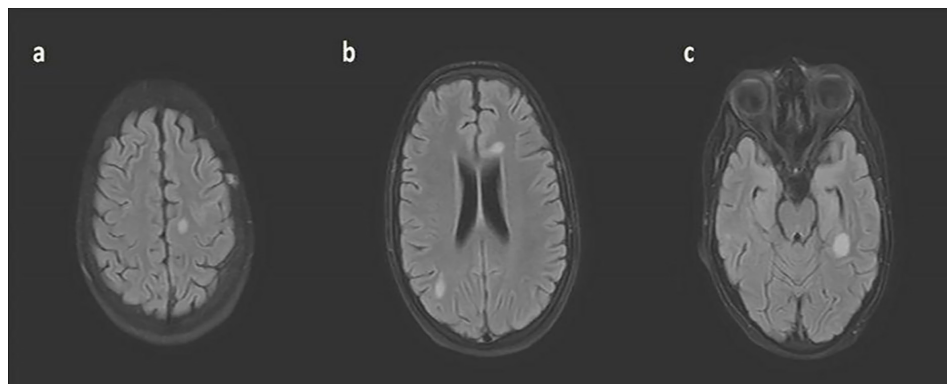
The 13-year-old treated patient diagnosed with Burkitt lymphoma had following lesions present: in the left paracentral subcortical area (a), next to the left segment of the corpus callosum genu (b), in the right posterior parietal area (b) and in the left temporal periventricular white matter (c). The hyperintense lesions detected at FLAIR sequence were found without significant round shaped edema rings. The presence of a corpus callosum lesion firstly raised suspicion for chemotoxic leukoencephalopathy. The lesions had no pathological contrast enhancement after the applied IV contrast material
